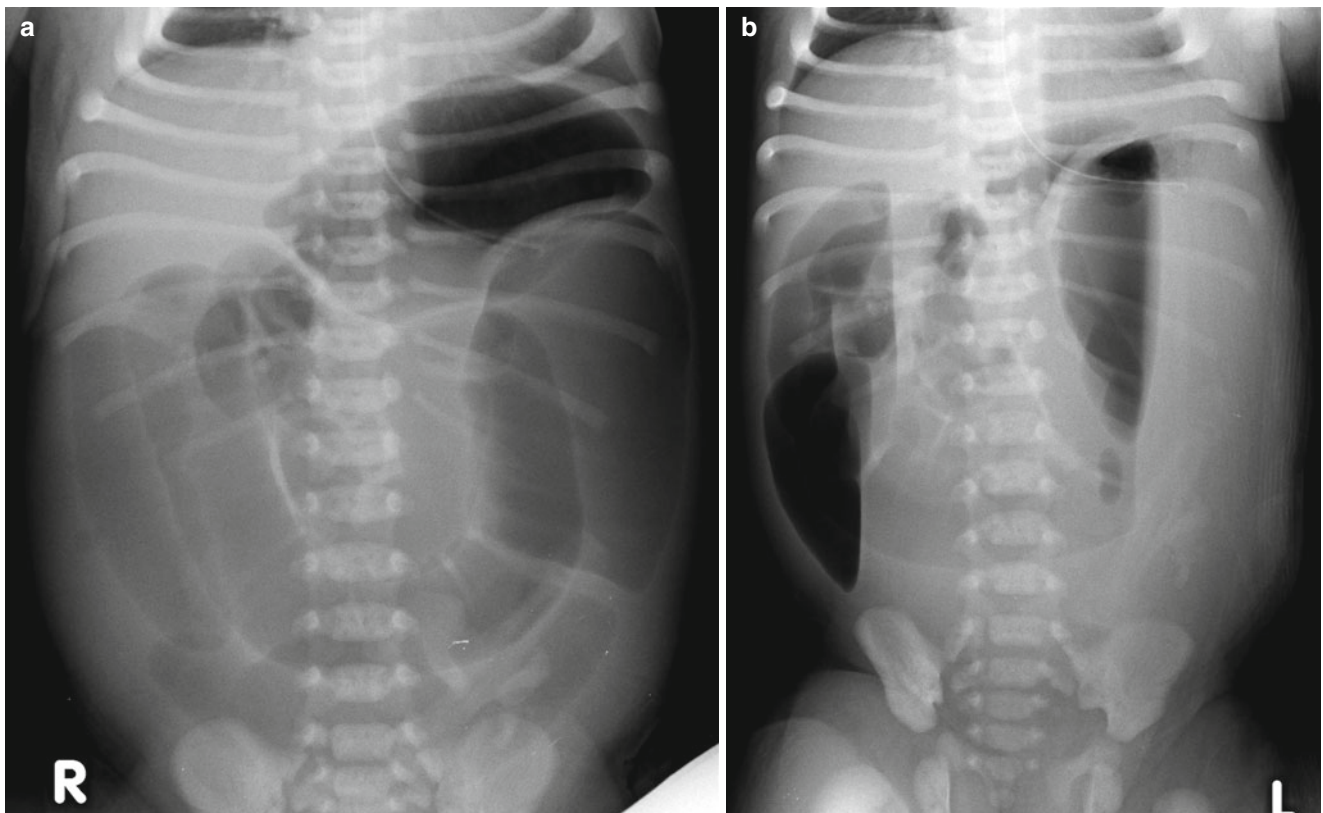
Distal jejunal atresia in a 1-day-old neonate with prenatal US diagnosis of bowel obstruction. Abdominal radiograph in supine (a) and left lateral decubitus (b) position show several dilated small bowel
